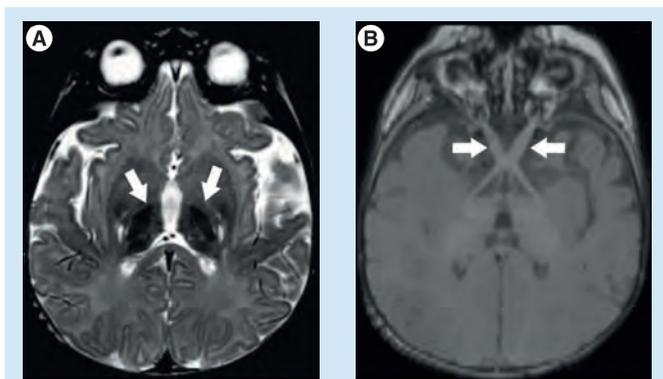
MRI in globoid cell leukodystrophy (Krabbe disease). (A) Signal changes in the bilateral thalami, (B) optic nerve enlargement.
